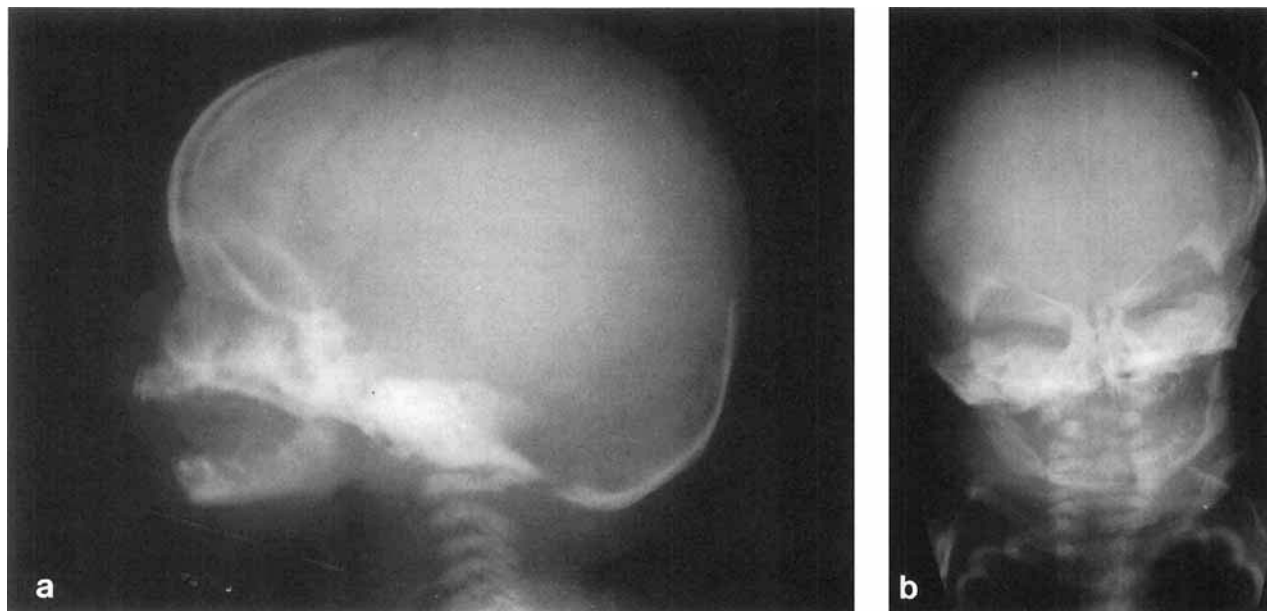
a: Patient 1. Lateral skull radiograph. Dolichocephaly with frontal dysplasia, unossified parietal calvaria, and hypoplasia of mandible. b: Patient 2. Frontal skull radiograph. Plagiocephaly; mildly hypoplastic mandible.
